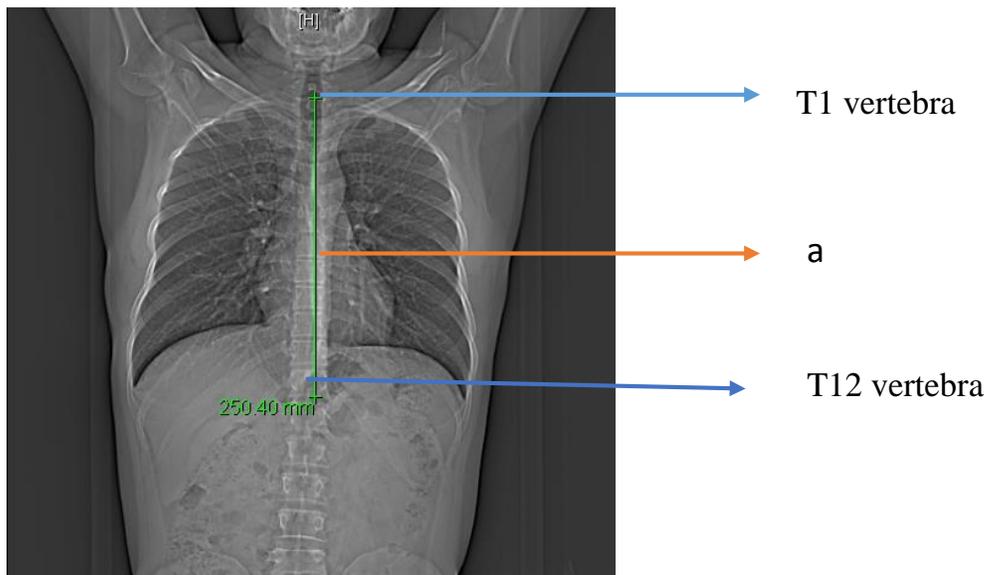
CT Thorax-Scan Length from Topographic Image- Vertical distance of CT thorax (Tv)
